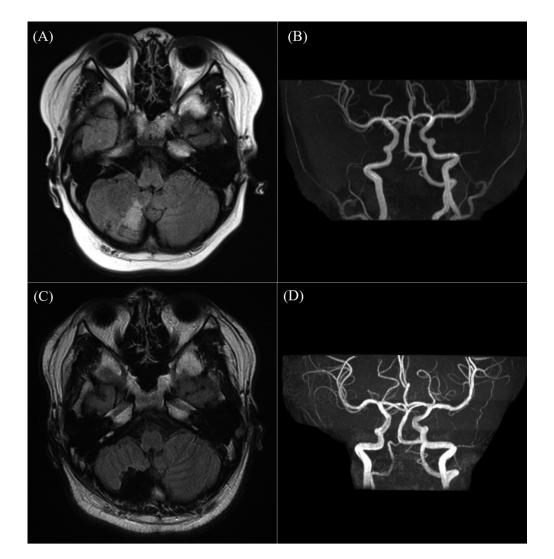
Magnetic resonance (MR) imaging (MRI) of the head of the patient. (A) and (B) are MRIs at first admission to our hospital at 8 years of age. (A) Fluid-attenuated inversion recovery image of axial section at the cerebellar level reveals right cerebellar infarction due to traumatic right vertebral artery dissection. (B) The right vertebral artery is not visualized on MR angiography. (C) and (D) are MRIs at 14 yr old.
